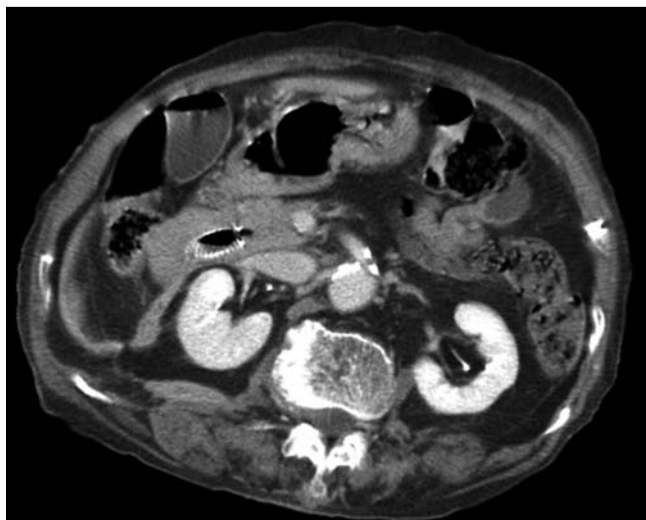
At 1 month, abdominal computed tomography (CT) showed a decrease in the size of the perirenal abscess, and a small cavity and fibrosis.
